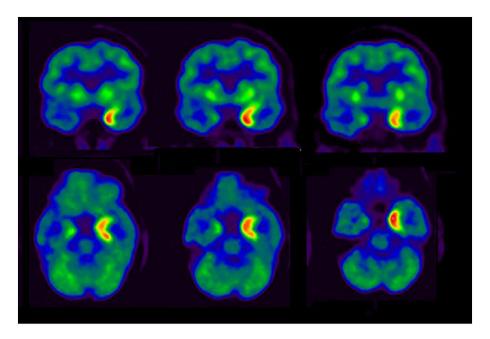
Hypermetabolism of left temporal lobe in a non-ictal brain 18FDG-PET.
